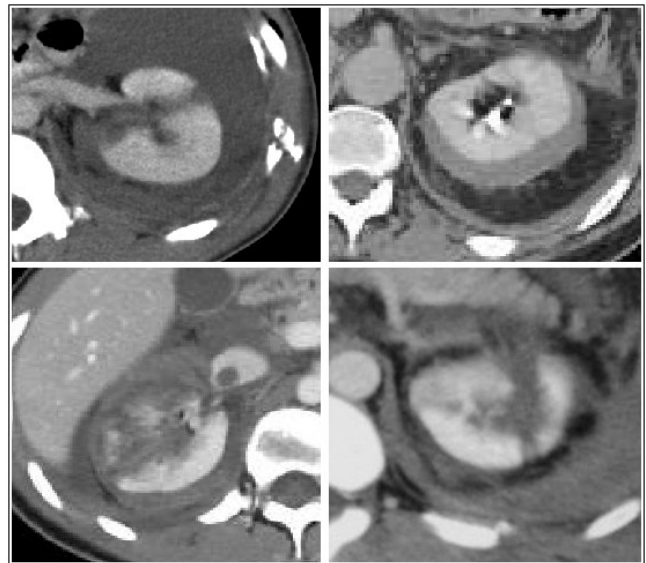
Computed tomographic examples of blunt renal injuries.
